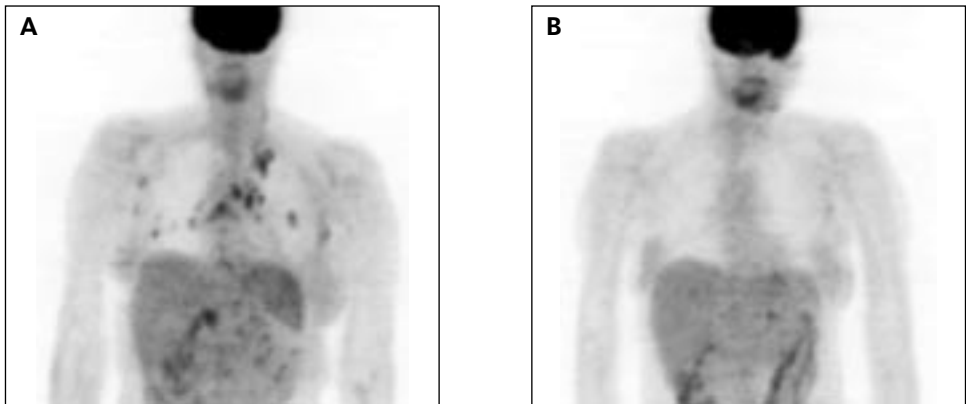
In a 45-year-old woman with *Staphylococcus aureus* septicemia and persistent fever during therapy, PET showed increased FDG-uptake in multiple lesions in both lungs, the mediastinum and in the upper abdomen (Figure 1A). Subsequently, chest CT also showed multiple lesions in both lungs and the mediastinum. Cholangitis caused by gallstones was confirmed by abdominal ultrasound and endoscopic retrograde cholangiopancreatography (ERCP). The fever disappeared within two days after ERCP. After three months, FDG-PET was normal (Figure 1B) and antibiotic therapy was discontinued.
